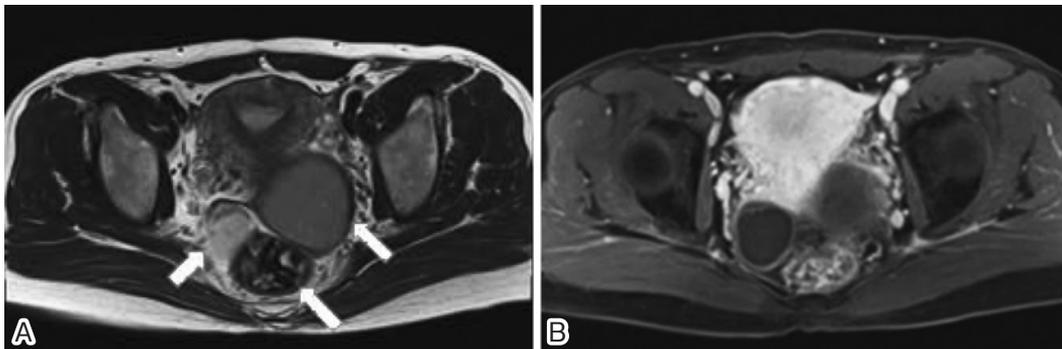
(A) T2-weighted magnetic resonance image shows the mass with a heterogeneous internal signal intensity with punctate high signal intensity (arrows). (B) Suppression of the high signal intensity of the lesion is observed on fat-saturated T2-weighted images
